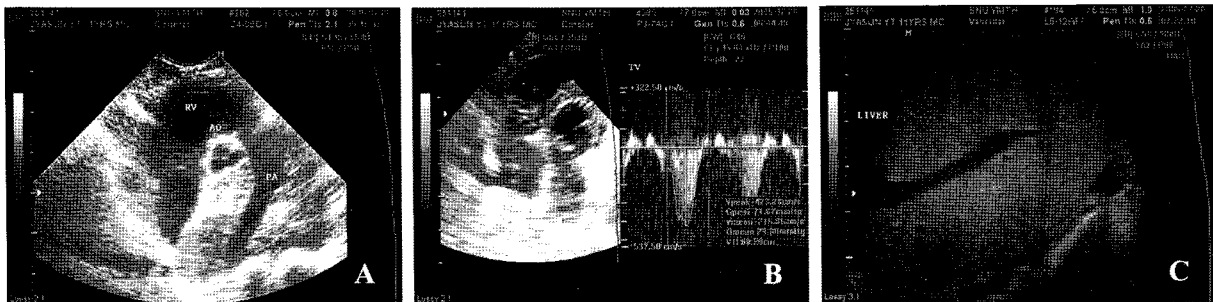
(A) A hyperechoic mass attached to the aortic root and adjacent pulmonary artery from a right parasternal short-axis view. (B) A high-velocity (4.23 m/s) tricuspid regurgitant flow from a left apical four-chamber view. (C) Diffuse fine echotexture and engorged hepatic vein within the liver.
